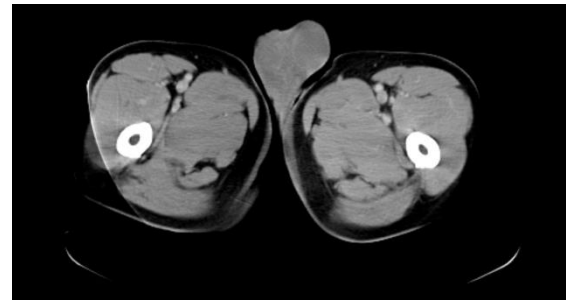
CT scan confirming the tumor.
